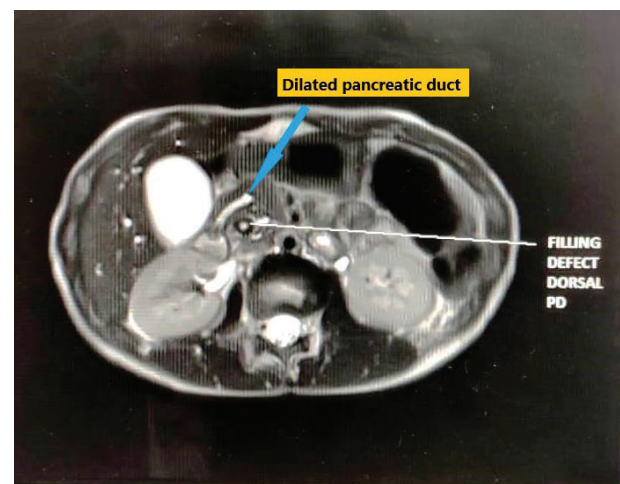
MRI photograph showing dilated sigmoid course of main pancreatic duct.
